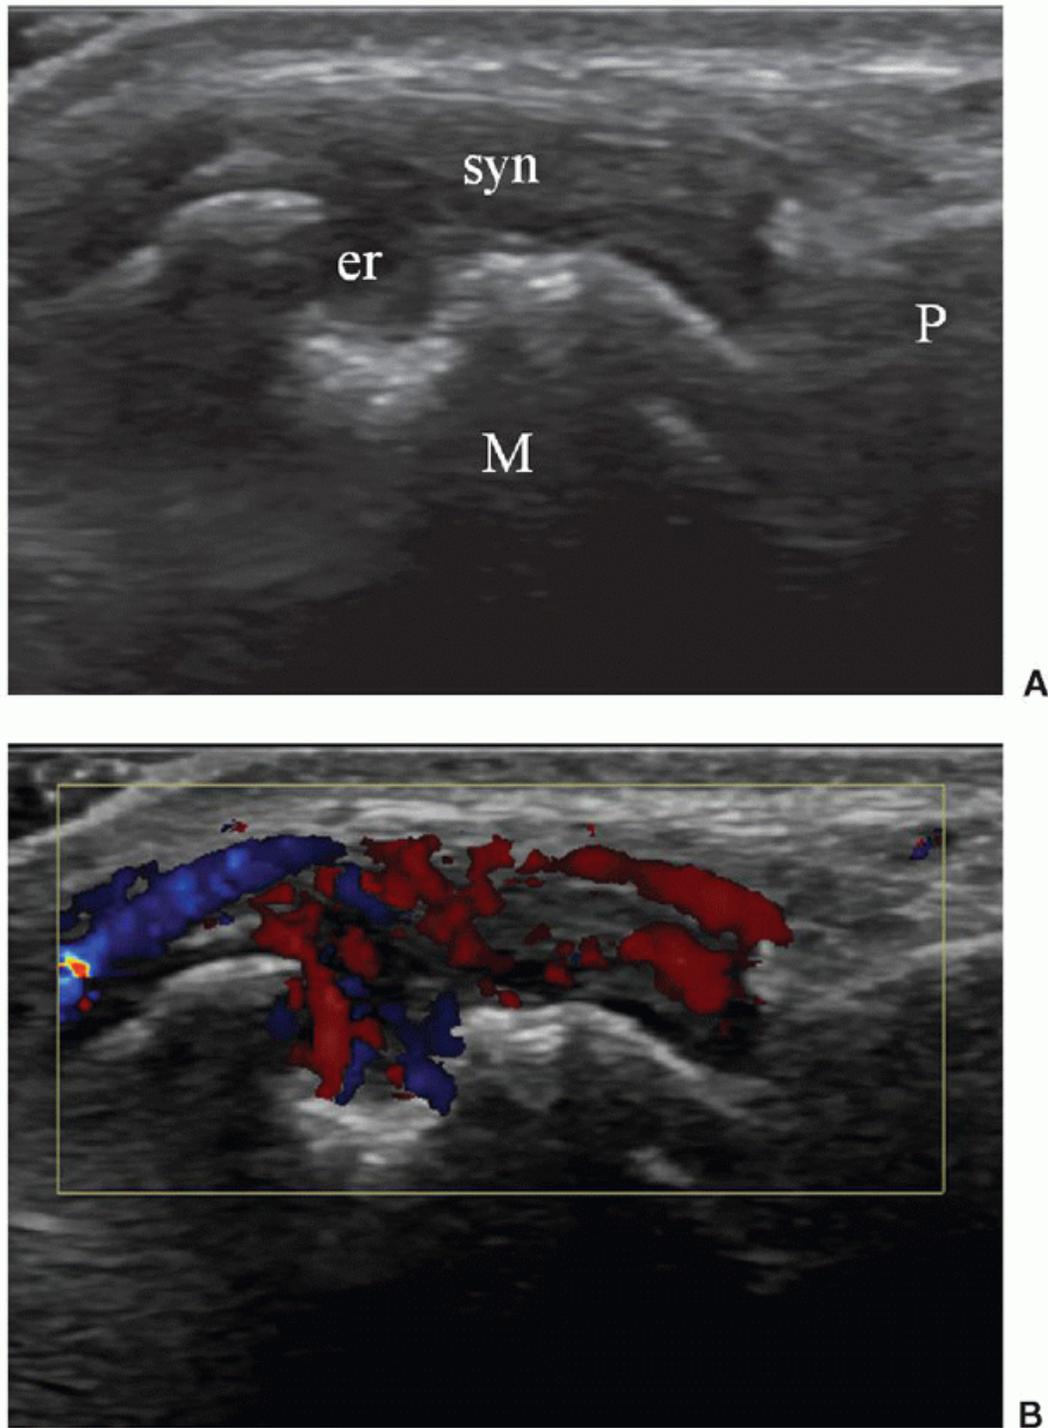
Dorsal longitudinal scans of second MTP joint in patient with RA. A: Synovial hypertrophy (syn) with erosion of metatarsal head (er). M, metatarsal head; P, proximal phalanx. B: Synovial hyperemia on color Doppler examination confirms active synovitis.
